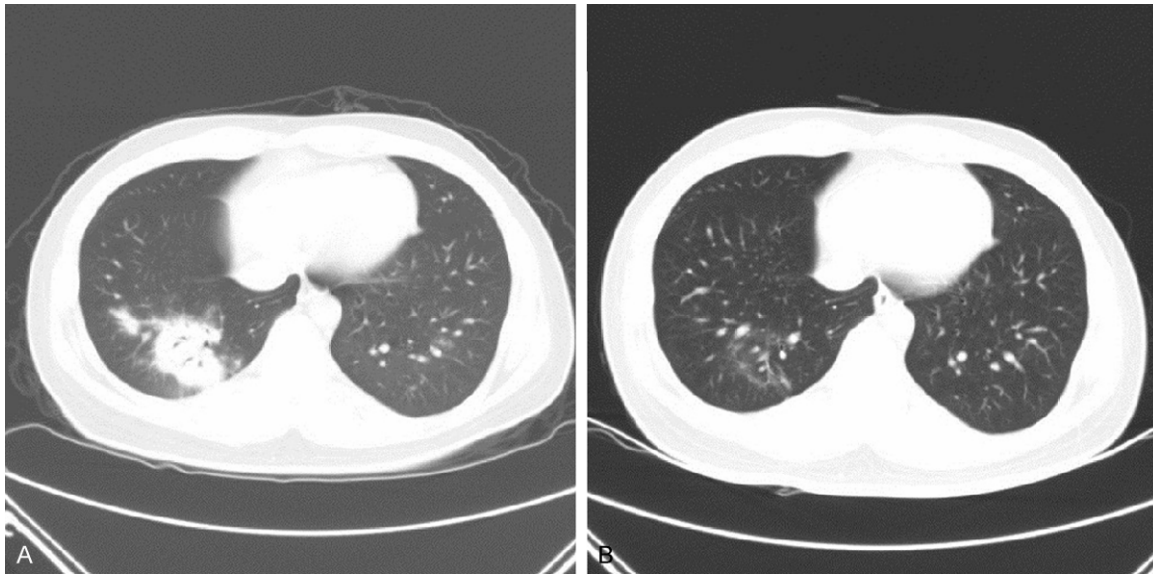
Chest CT scan showed mass in right lower lobe (A) before treatment, lesions significantly absorbed after treatment (B).
